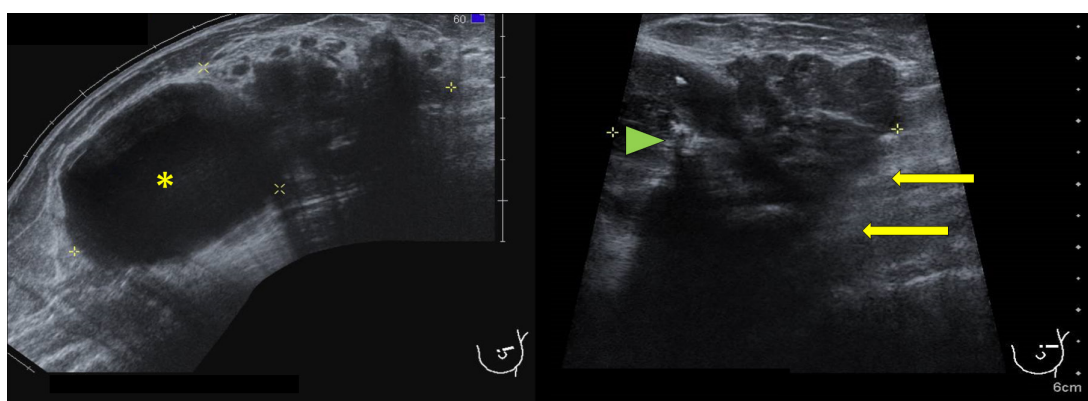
Ultrasound of the left breast shows a 13cm solid-cystic mass. There is an eccentrically located cystic component with circumscribed margins (asterisk), and an adjacent lobulated hypoechoic solid component with partially indistinct margins and posterior acoustic shadowing (long arrows). Internal echogenic foci with posterior acoustic shadowing (arrow head) correspond with the coarse calcifications on mammography.
